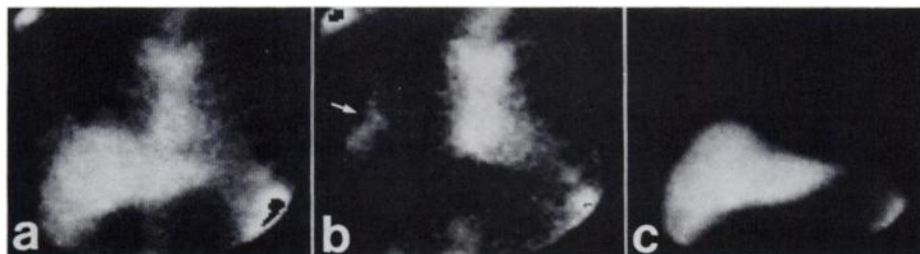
(a) Indium-111 leukocytes. (b) Subtraction of liver area. (c) Tc-99m(Sn)colloid. Case 3. A 42-yr-old male patient, with pleural effusion by chest radiograph. Lung-liver scintigraphy was normal. Subtraction scintigraphy showed focal activity, more likely in pleural than in subphrenic space. Drainage by high costal resection was carried out.
